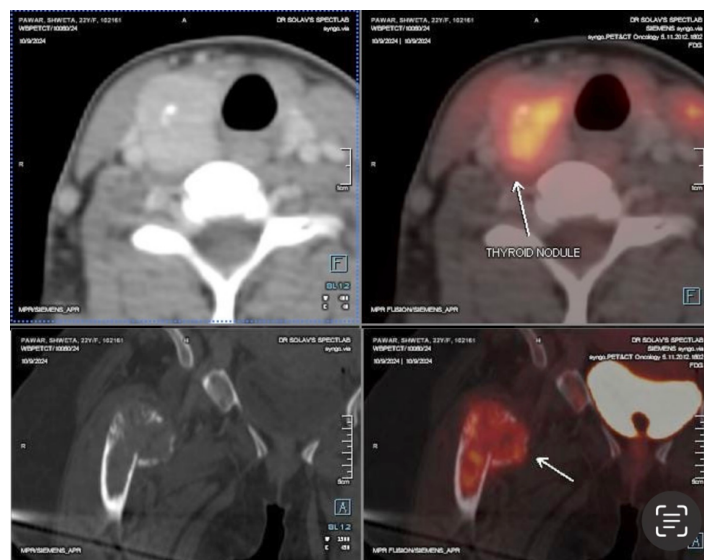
PET scan showing FDG-avid module.
